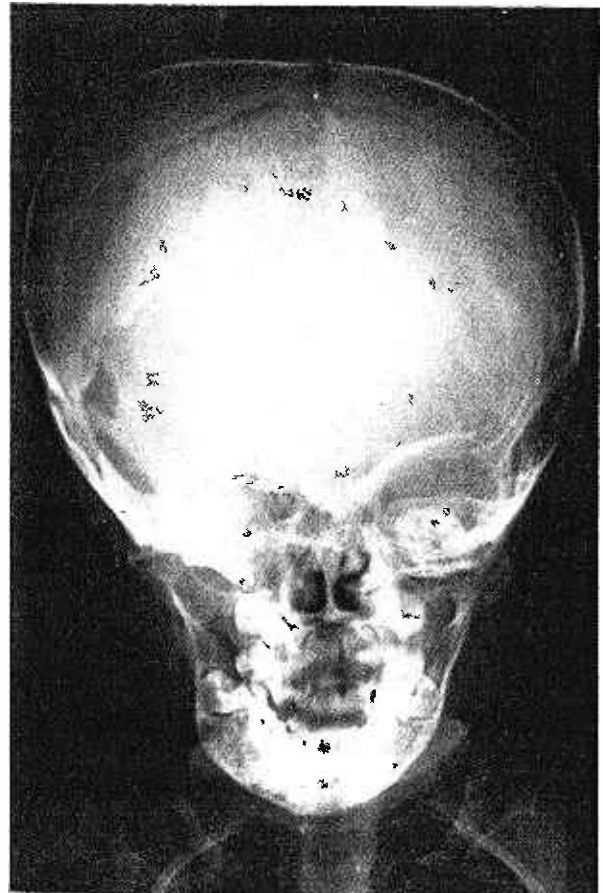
Case 2, X-ray skull showed strophic areas over lambda and right occipital region.
